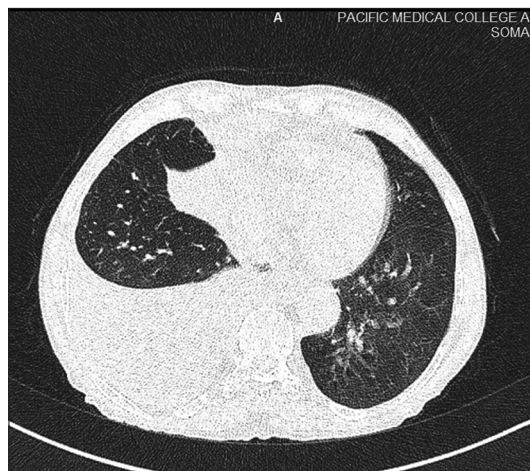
Computed tomography lung window showing pleural effusion
